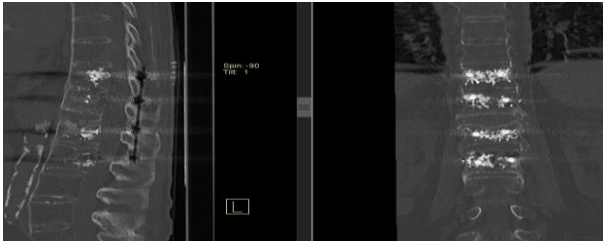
B. Postoperative CT reveals good positioning of the arthrodesis material.
